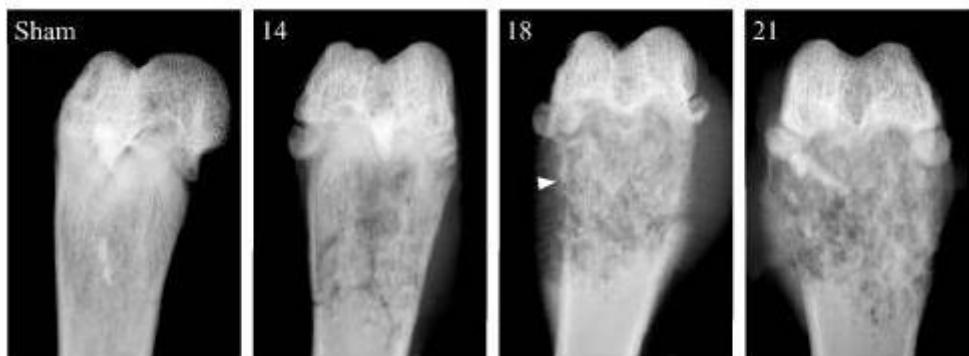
Figure adapted from Dore-Savard *et al.* 2010. Figure shows radiographs of sham-operated and CIBP femurs at 14, 18 and 21 days after surgery. At Day 14, decreased bone density is observed in the medullar canal of the bone while cortical integrity is maintained. At Day 18, the cortical line is blurred and cortical integrity is partially compromised. By Day 21 the bone shape is irregular.
